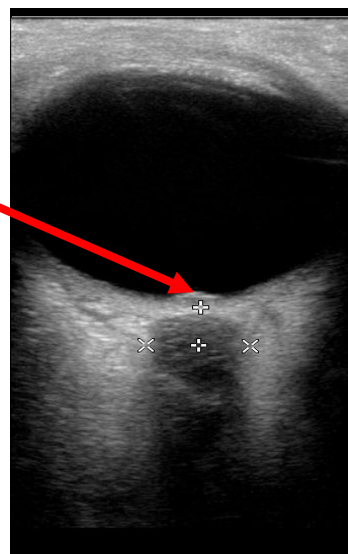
Axial ultrasound image of ONS
